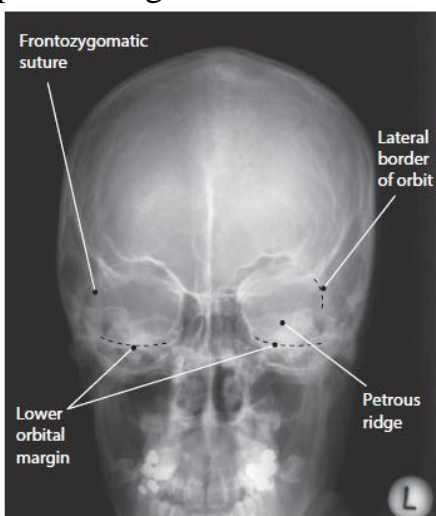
OF radiograph showing anatomical features.
